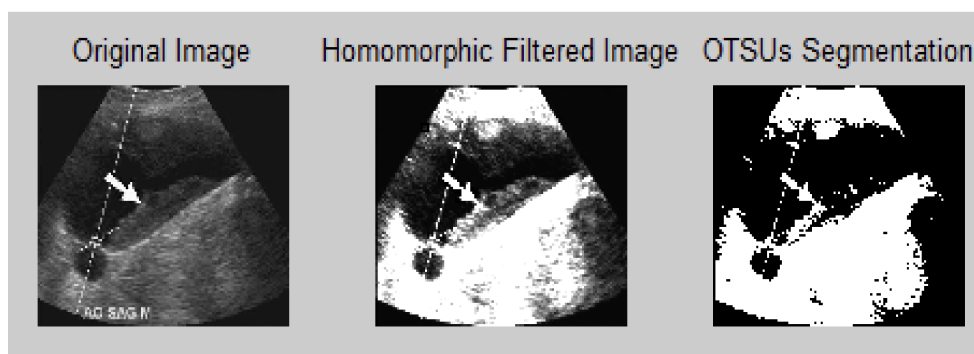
Homomorphic filtering and Otsu segmentation of ultrasound cardiac duplex screening samples [18].
